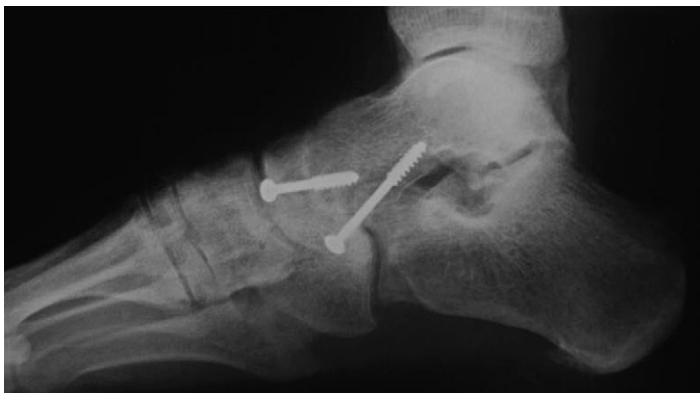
A 1-year postoperative lateral radiograph demonstrating consolidation and correction following isolated talonavicular arthrodesis. Note the correction in the calcaneal inclination angle and the talar-first metatarsal angle.
